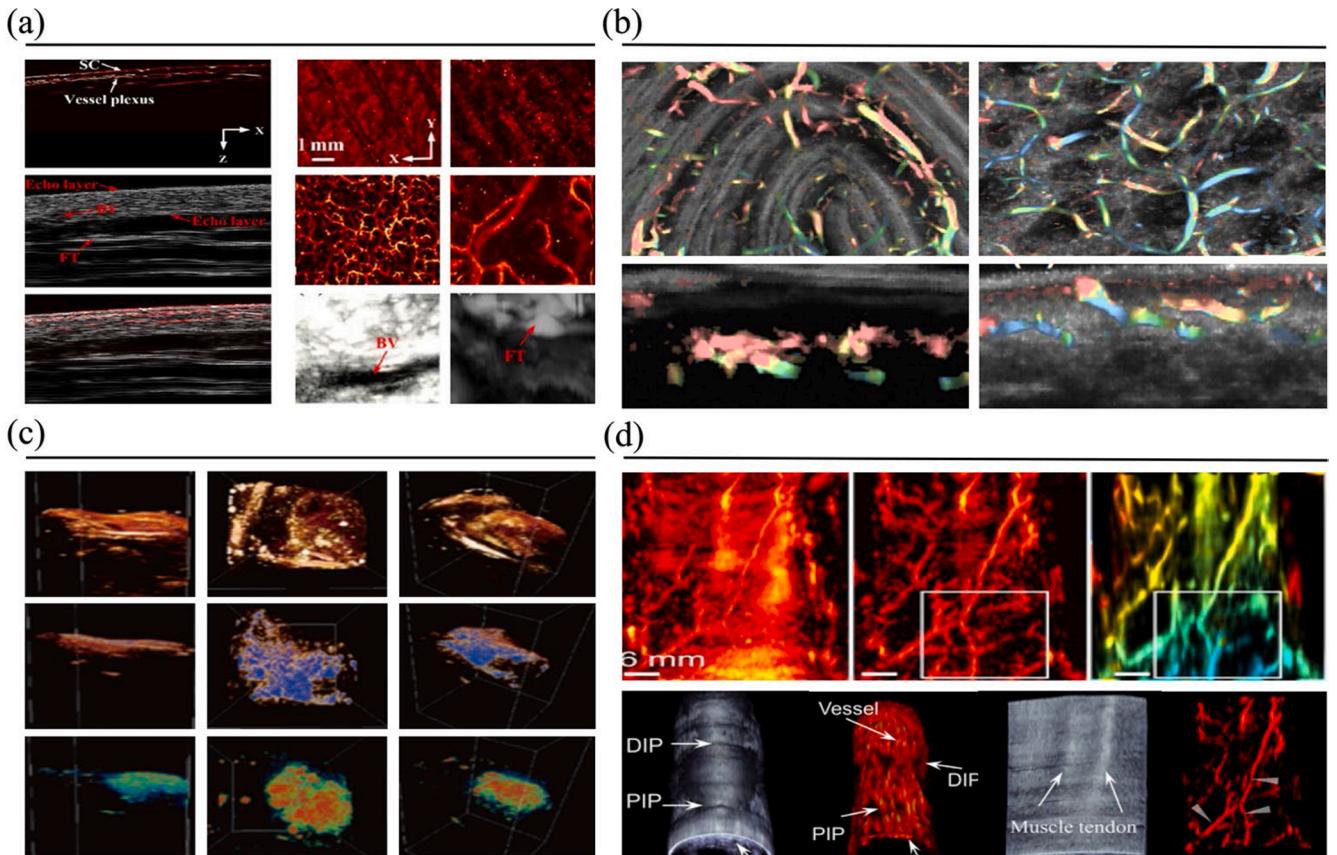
PAM-US skin imaging applications. (a) In vivo imaging of the human palm. The hybrid PA and US image of the human palm. PA lateral MAP image of epidermal (0–90 μm), epidermal-dermal junction (90–210 μm), dermis (210–350 μm) and vessel plexus (350–1500 μm). US volume projection image of big vessel at a depth of 1.5–2.6 mm. US volume projection image of fibrous tissue at a depth of 2.6–5 mm. SC, stratum corneum. BV, blood vessel. FT, fibrous tissue [100]. (b) Examples of PAM-US images of bird's eye [117]. (c) Reconstructed 3D images with the visible light and NIR light AR-PAM data and the US data from different perspectives. First line, US imaging results. Second line, photoacoustic imaging results with visible light excitation, and third line, photoacoustic imaging results with NIR light excitation [118]. (d) Photoacoustic and ultrasonic imaging of finger region skin.
